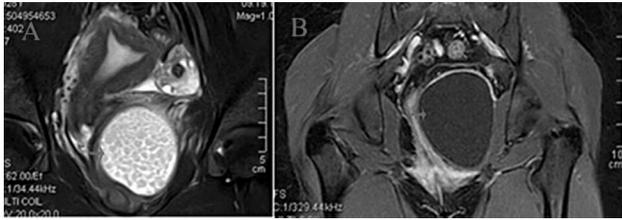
Sagittal T2-weighted MRI (A) showing a vaginal dermoid cyst located in the paravaginal space with thin, smooth cyst wall (arrow). Postcontrast coronal T1-weighted MRI (B) showing no remarkable enhancement, indicating benign nature of the vaginal cyst (arrow).
